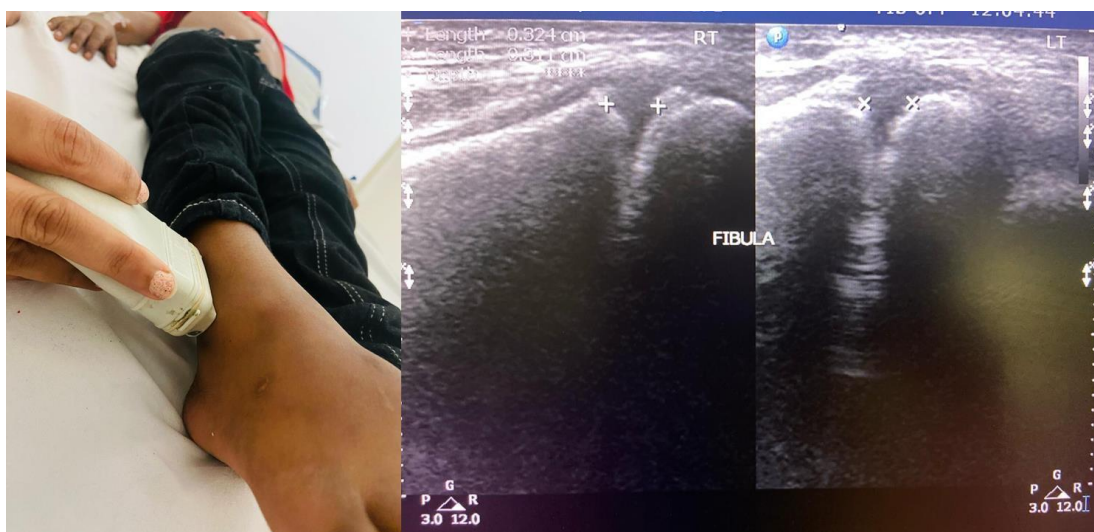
Clinical image of position of the transducer over lateral surface of fibula . Ultrasound image shows measurement of width of fibular physal plate.
